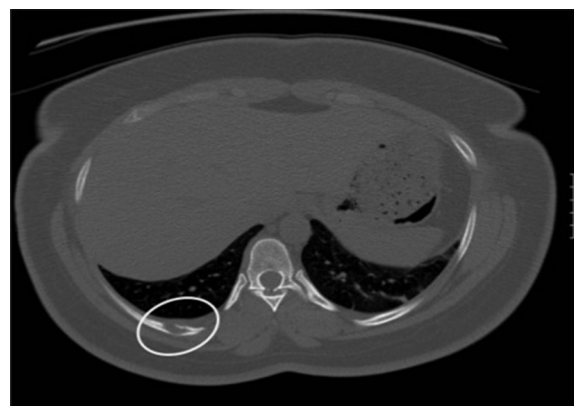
Initial CT scan of the abdomen and pelvis in the study patient revealing an incidentally found right ninth rib lytic lesion (circle).
